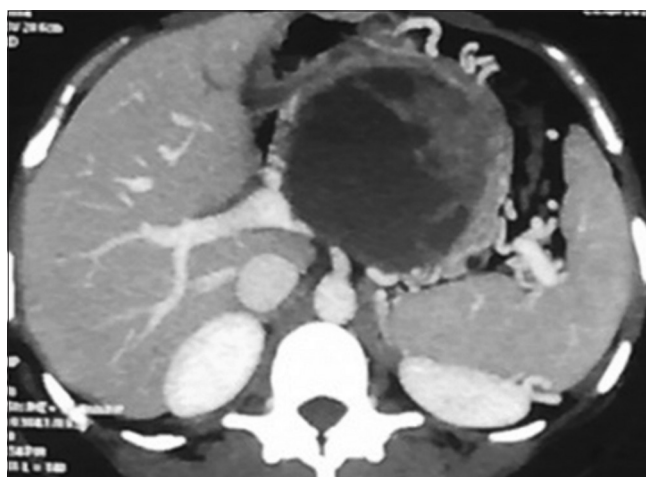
28-year-old female with a mass in the abdomen. Axial contrast-enhanced computed tomography shows large, well-encapsulated mass in the body of pancreas showing solid enhancing and cystic nonenhancing components. The mass is causing mass effect on the portal vein with multiple, resultant perigastric, splenic hilar, and lienorenal collaterals
